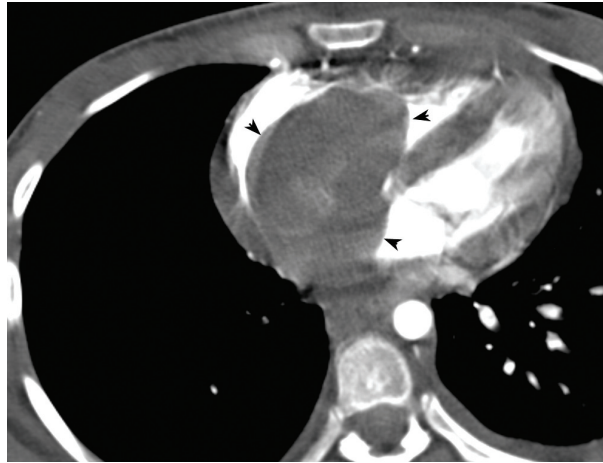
Contrast-enhanced CT scan of chest at the level of the right ventricle shows a large tumour thrombus as a filling defect in the right atrium and ventricle (arrowheads). Hardly any enhancing pulmonary arteries are identified on the right side
